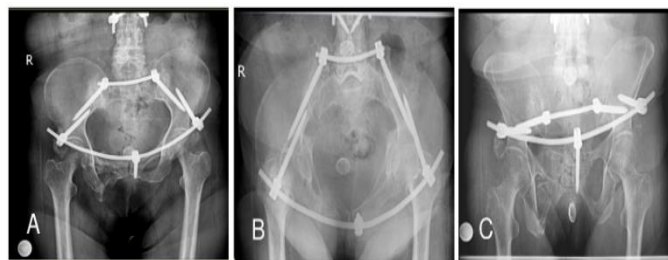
Post-operation control X-Rays. A: AP view. B: Inlet view. C: Outlet view
